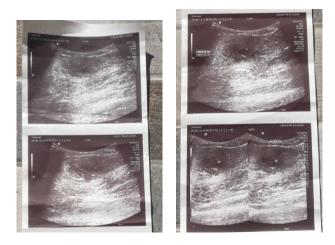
Ultrasound of the lesion
